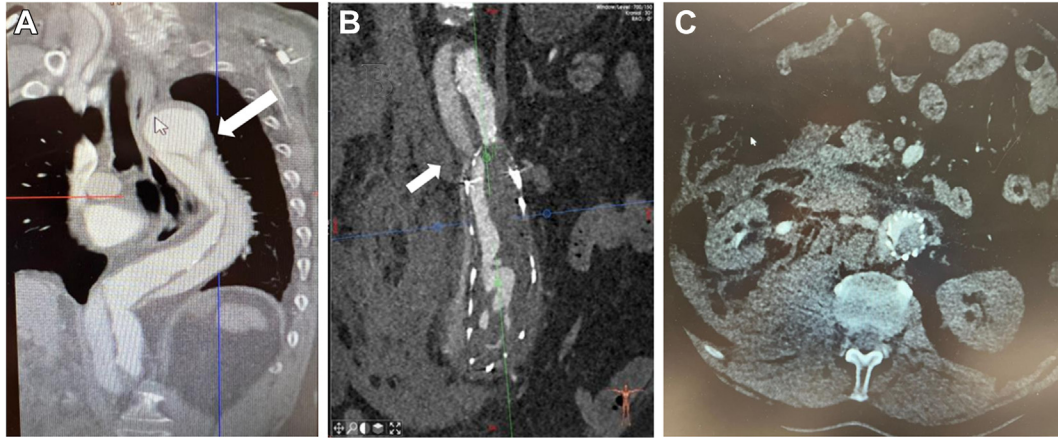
Preoperative computed tomography (CT) images of the aorta demonstrating acute type B aortic dissection (ATBD) at the level of the descending aorta (A), hematoma after infrarenal rupture of the false lumen of the ATBD after endovascular aneurysm repair (EVAR) with AFX stent graft placement (B), and no perfusion of the left renal artery after ATBD (C). Arrow indicates the entry tear (A) and reentry tear (B) on the CT scan.
